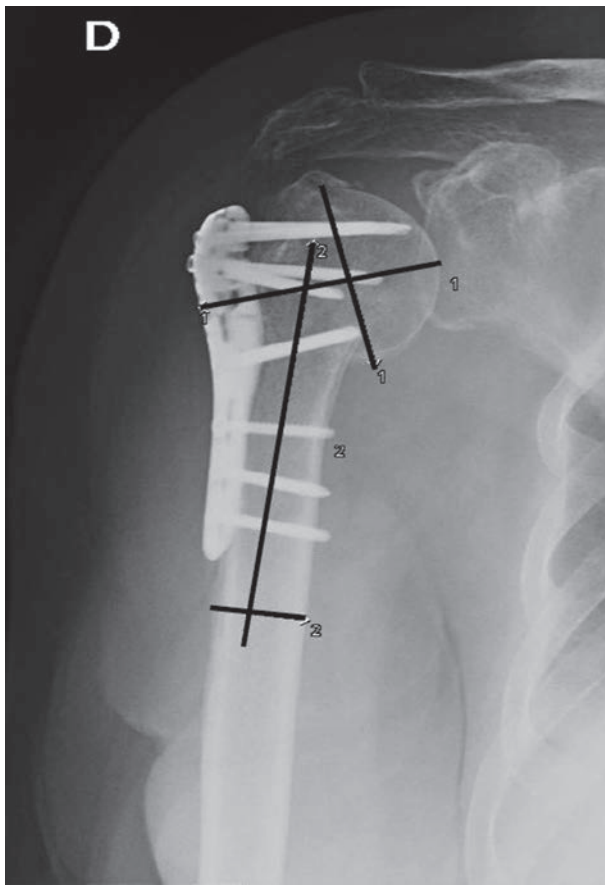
Radiograph at 6 months of follow-up (HHSA 111,43°) and at 9 months of follow-up (HHSA 111,40°) respectively highlights varus malalignment of the humeral head.
